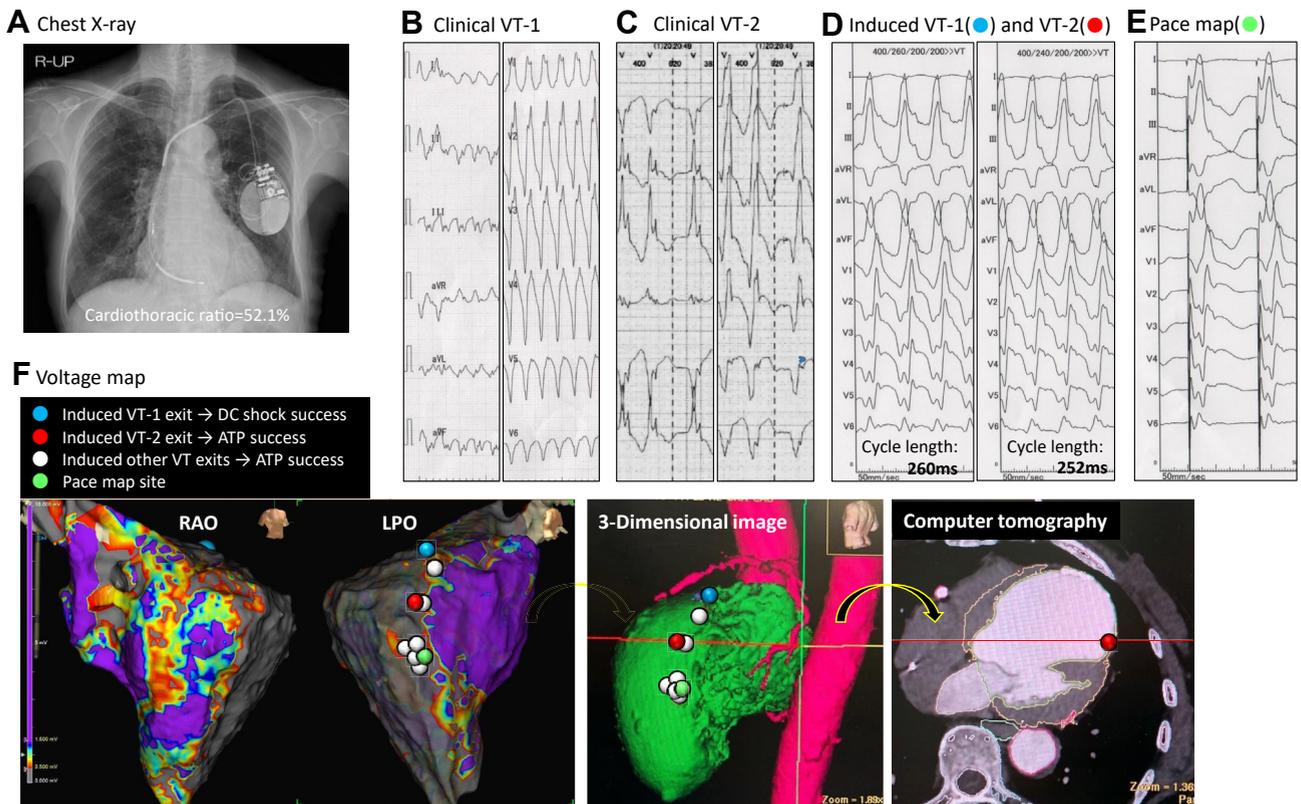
Electrophysiological findings. A: Chest radiograph with implantable cardioverter-defibrillator insertion and mild cardiac enlargement. B, C: Two types of clinical ventricular tachycardia (VT). D, E: Induced VTs and pace map morphology differed from clinical VTs. F: Multiple VT exits, and pace map site marked in the border zone of the endocardial voltage map. ATP = antitachycardia pacing; DC = direct current; LPO = left posterior oblique view; RAO = right anterior oblique view.
